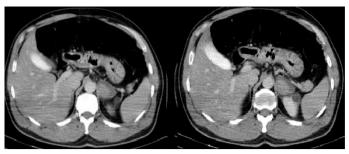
Control abdominal CT; regression of hematoma and increased appearance of central hyperdensity (Axial view of enhanced abdominal CT scan)
